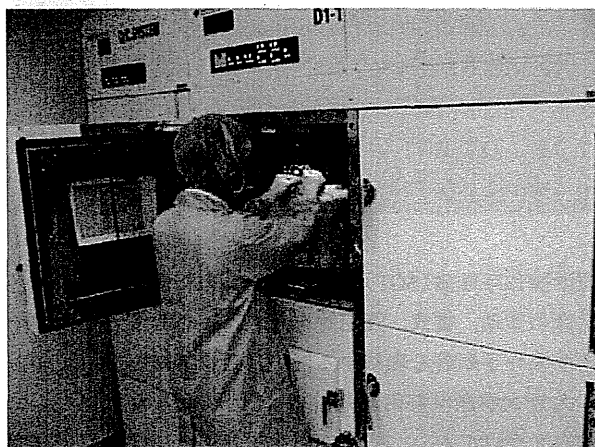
ホットセル内¹⁸F-FDG自動合成装置における装着作業
